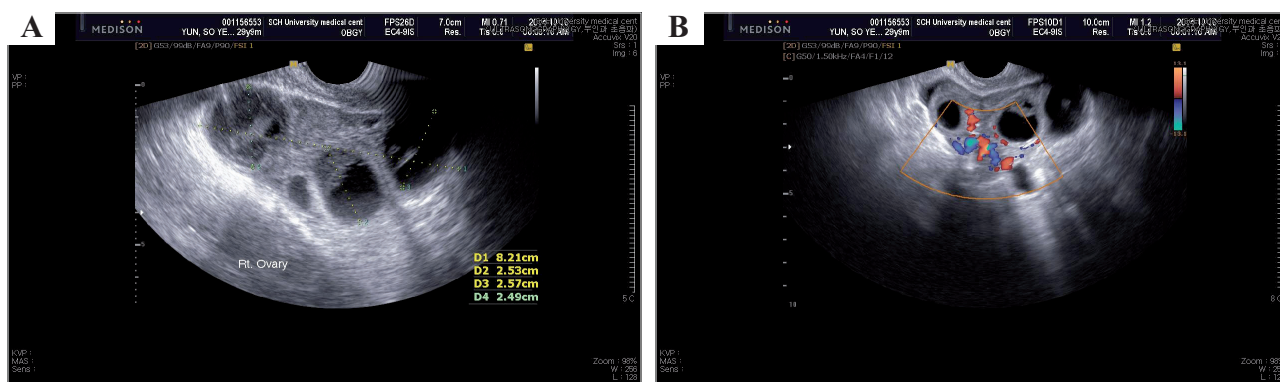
(a) Right ovary is enlarged, larger than 8.0 cm suggesting OHSS. (b) Color Doppler showed flow asymmetry is observed, with reduction of arterial flow.
